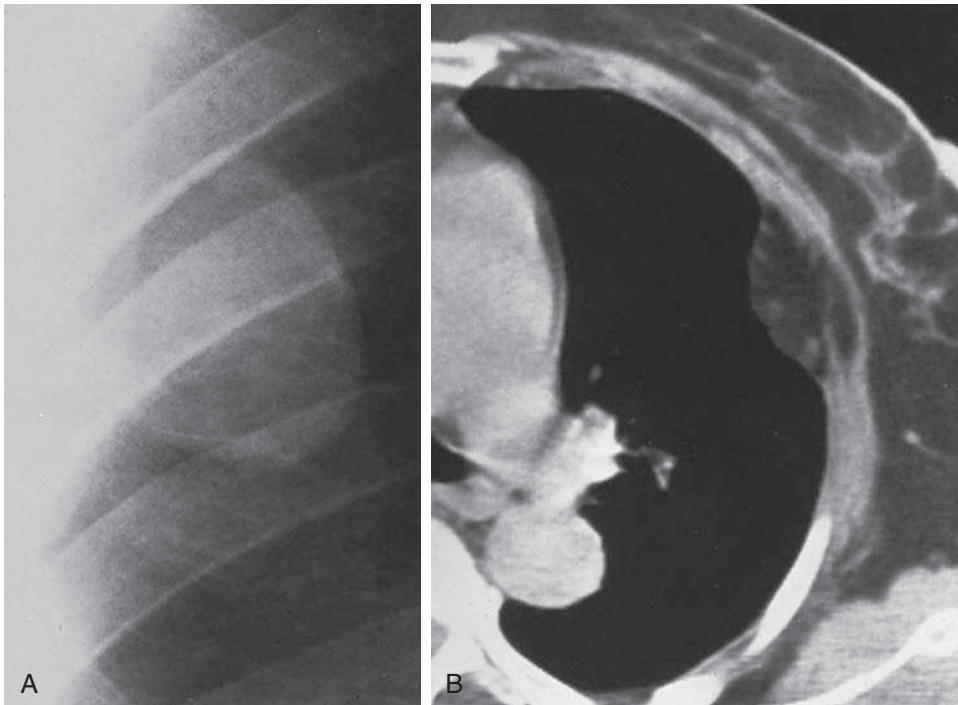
A, Chest wall lipoma appears to be of tissue opacity, in contrast to aerated lung. Location of lipoma against the lateral chest wall and its incomplete border (sharp medial but absent lateral border) suggest that it is nonpulmonary. There is no rib destruction to confirm chest wall origin. Both chest wall and pleural masses should be considered in differential. B, Computed tomography scan of another patient with a chest wall lipoma shows a mass that is of greater opacity than the aerated lung but less opaque than the musculature of the chest wall. This intermediate fat attenuation mass is shown to extend through chest wall muscles. (Case courtesy of Thomas L. Pope, Jr., M.D.)
